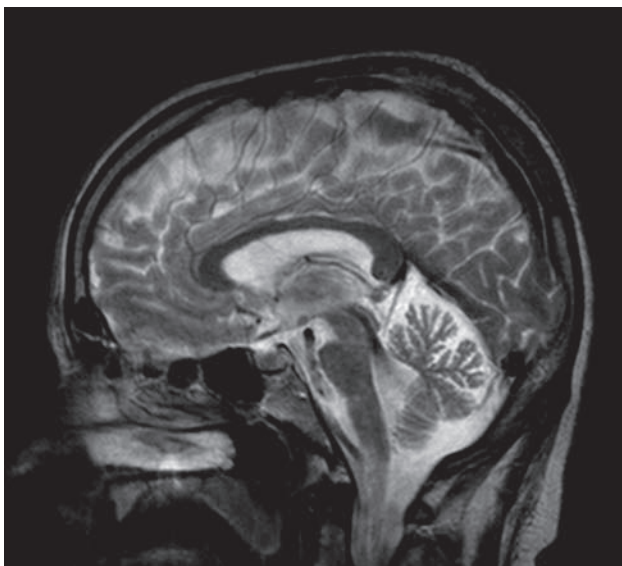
Spinocerebellar ataxia type 2. Cerebellar and pontine atrophy on a sagittal T2-weighted MRI.
